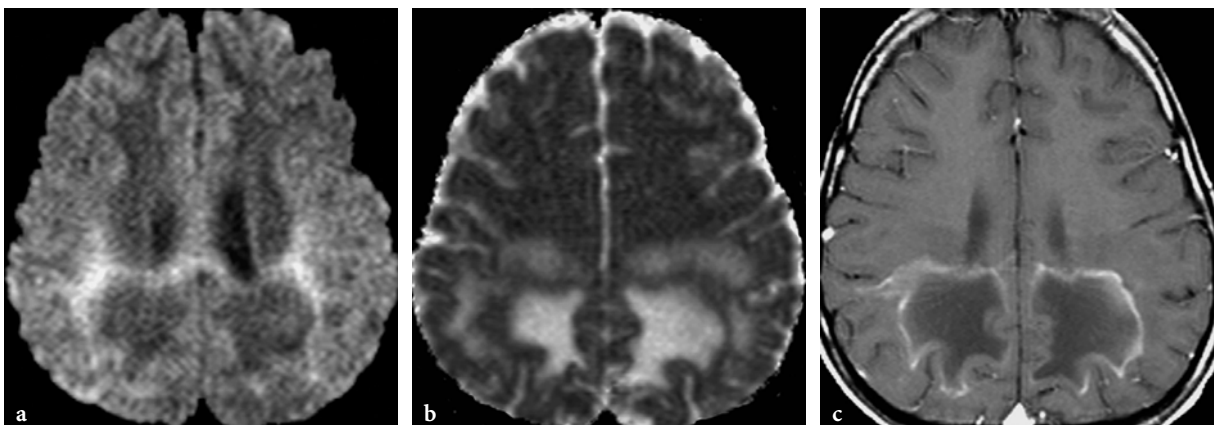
Diffusion-weighted and gadolinium-enhanced T1-weighted imaging findings in an 11-year-old male patient with X-linked adrenoleukodystrophy (same patient as in Fig. 13.104). a Axial diffusion-weighted echo-planar image ($b = 1000s$). The central (burned-out) zones of the parieto-occipital lesions are markedly hypointense, the intermediate (inflammatory) zone is markedly hyperintense, and the peripheral (demyelinating) zone is faintly hyperintense. b Axial apparent diffusion coefficient (ADC) map image. This image suggests that the central burned-out zone is characterized by isotropically increased water diffusion and the inflammatory zone by relatively restricted water diffusion. In the most peripheral demyelinating zone, the hypersignal on diffusion-weighted image is most probably due to T2 shine-through artifact. c Gd-enhanced axial T1-weighted spin-echo image. The contrast enhancement is confined to the inflammatory zone
